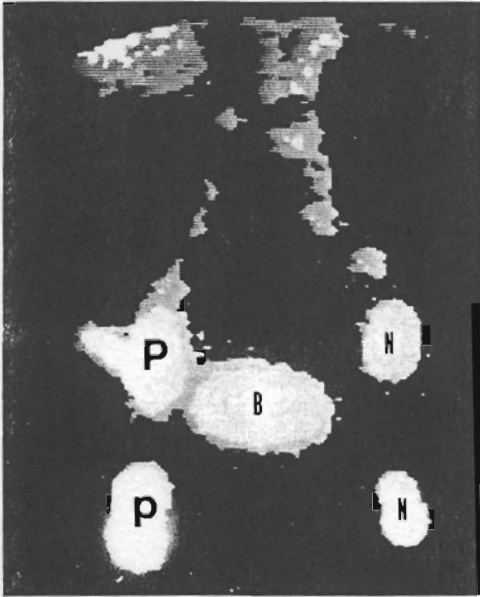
Articular lymphoscintigraphy ( $^{99m}\text{Tc}$ -labeled dextran) imaged at 6 hours after knee joint injection with  $2\text{mCi}$  in a patient with unilateral degenerative osteoarthropathy. On the pathologic side (P), more intense accumulation in inguinal and lumbar paraaortic lymph nodes is seen compared to the normal (N) side. B=bladder.
